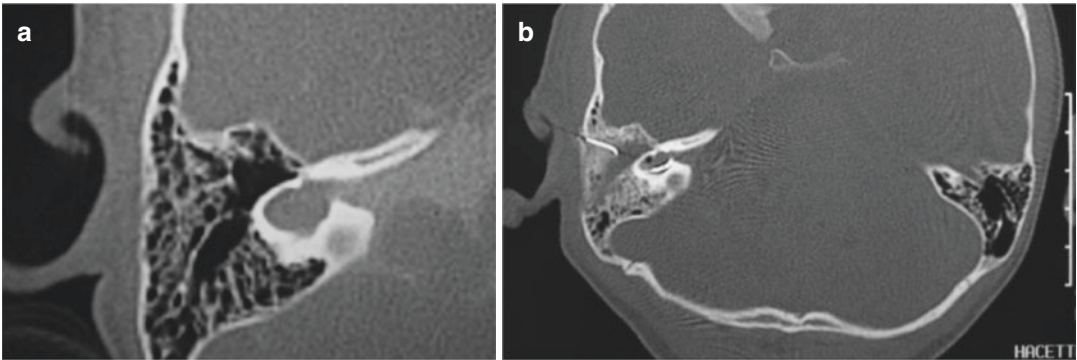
(a) Preoperative CT showing CC on the right side, (b) HRCT showing electrode placement in CC
